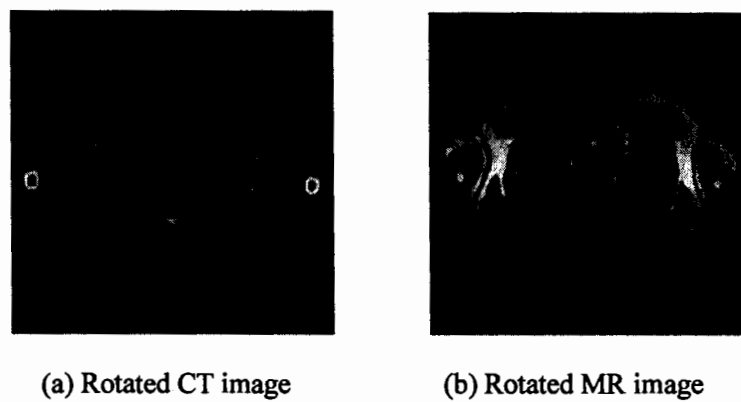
Rotated CT and MR Images of Chest by Proposed Method
